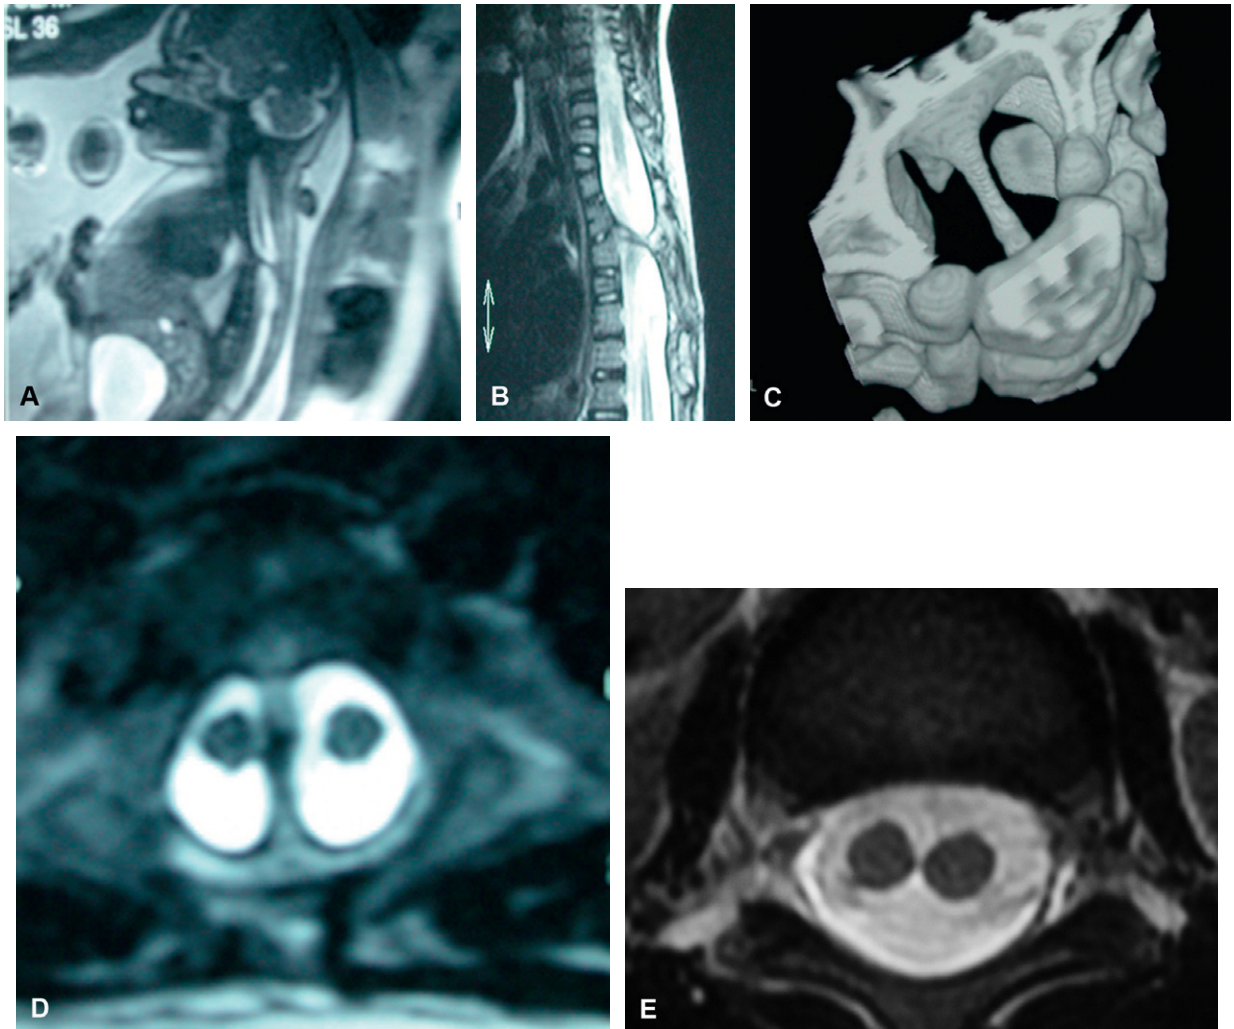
Diastematomyelia. (A) Antenatal sagittal MR. Type I with bony spur (arrow). (B) Postnatal sagittal MR. Same child. (C) Type I diastematomyelia. CT-scan 3D view. (D) Type I diastematomyelia. Axial T2-weighted MR. 2 hemi-spinal cord separated by a complete bony spur. (E) Type II diastematomyelia. Axial T2-weighted MR. 2 hemi-spinal cord in a unique dural sac without bony spur.
